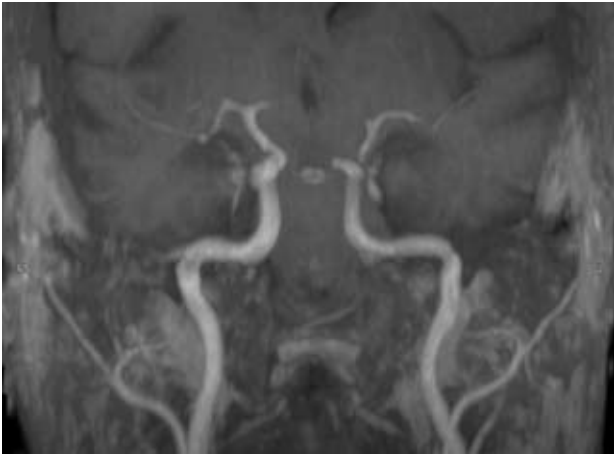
Coronal slab Maximum Intensity Projection MRI showing normal carotid arteries bilaterally.
